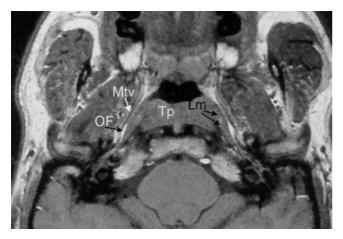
T1-weighted MR image with the scan plane angled 30° forward and downward relative to the horizontal plane. Mtv = tensor veli palatini muscle, OF = Ostmann fat pad (note the typical posterolateral broadening), Tp = pharyngeal tonsil, Lm = medial lamina of tubal cartilage. Male 25 years of age.
